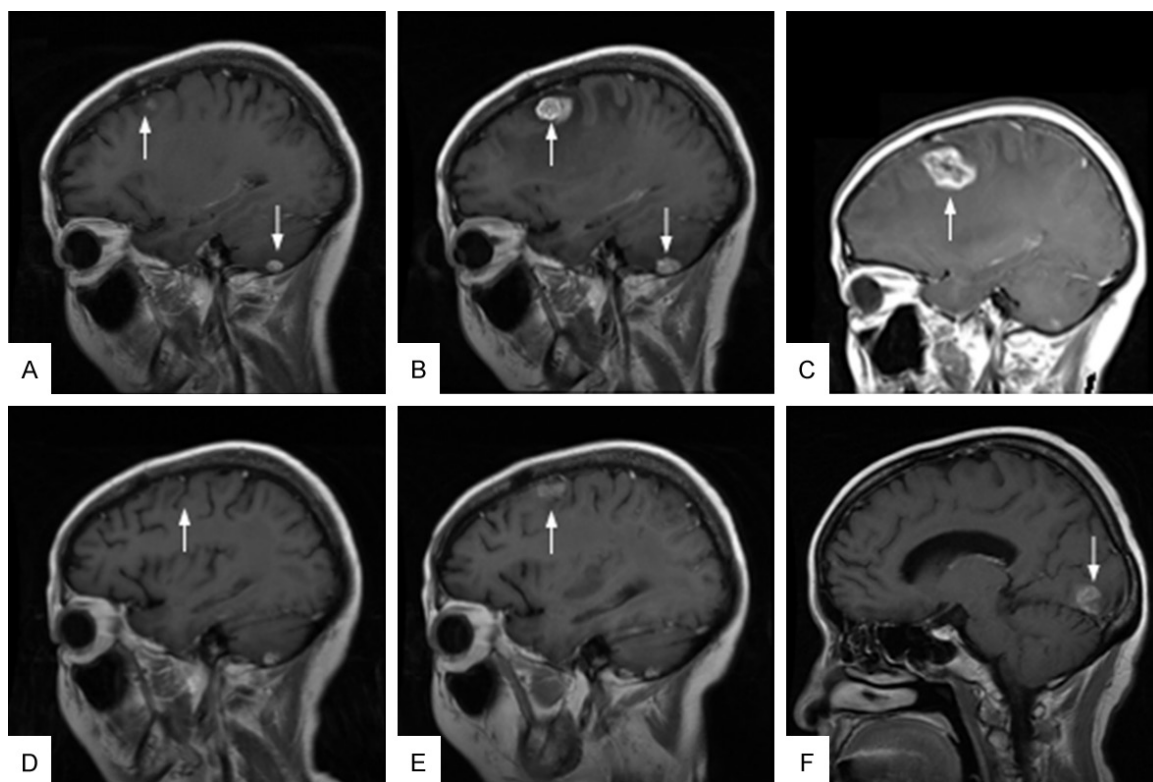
Magnetic resonance imaging (MRI) of the brain after different therapies. A. Metastases appeared in the left frontal lobe and cerebellum after postoperative radiotherapy and chemotherapy (February 2012). B. Enlargement of both metastatic sites of the brain during chemotherapy administration (cisplatin and pemetrexed) [November 2012]. C. Enlargement of the metastasis in the frontal lobe 4 months after sequential therapy with docetaxel and afatinib (May 2013). D. The brain lesions decreased dramatically after crizotinib treatment for 8 months (January 2014). E, F. Enlargement in the frontal lobe of brain after crizotinib treatment for 10 months, with a new metastasis appearing in the occipital lobe (March 2014).
